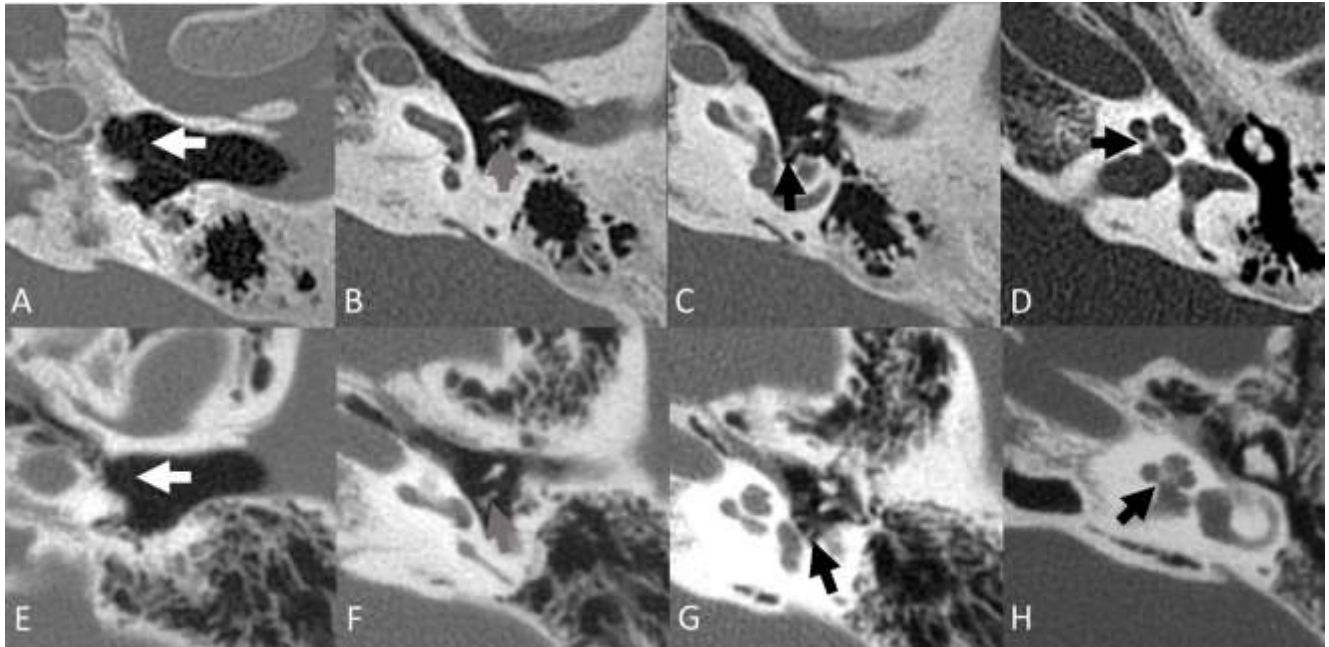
(A-D) Left temporal bone CT images of a 14-year-old male from PCD-CT. The axial CT images show anatomical structures, including the tympanic membrane (A, arrow), incudostapedial joint (B, arrow), stapedial crus (C, arrow), and cochlear modiolus (D, arrow). Both readers rated a score of 4 for all anatomical structures and overall image quality.
